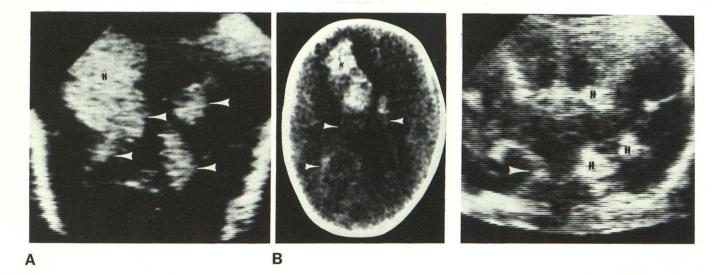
Case 2. A, Semiaxial sonogram. Large echogenic area involves much of right frontal lobe (H) representing intraparenchymal hemorrhage. Continuity with intraventricular blood (*arrowheads*). B, CT scan. Large right frontal lobe hemorrhage (H). Intraventricular blood (*arrowheads*).
